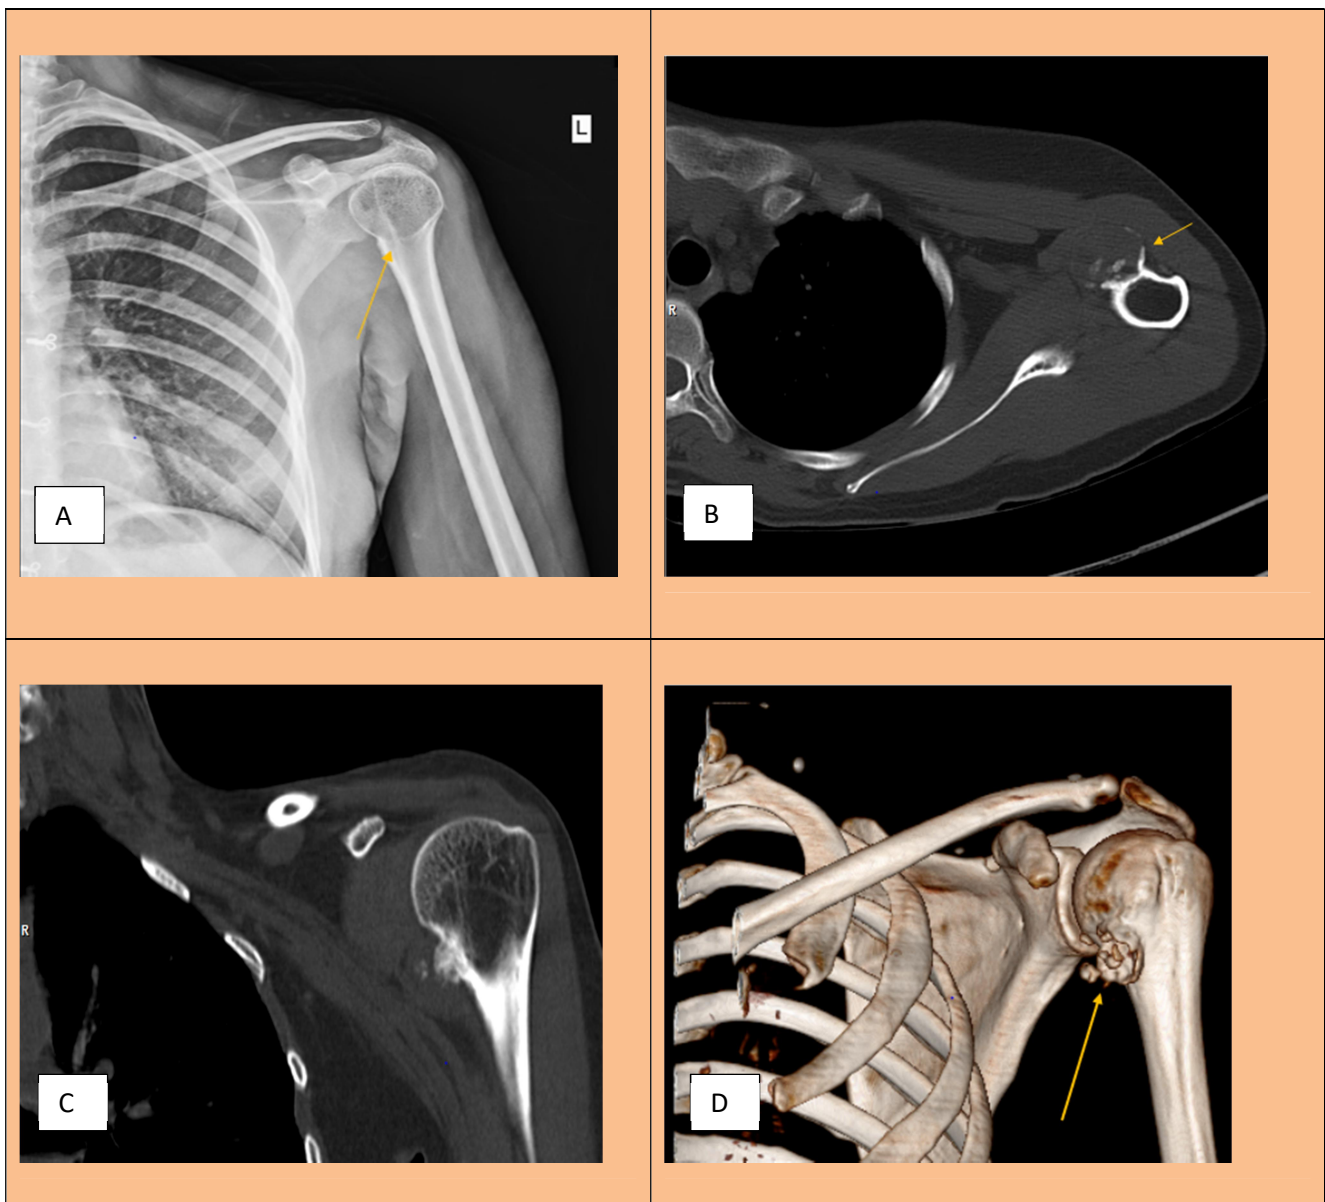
(A) Radiograph showing solitary osteochondroma arising from neck of humerus. (B,C,D,) CT scan of left shoulder showing solitary, pedunculated osteochondroma.
